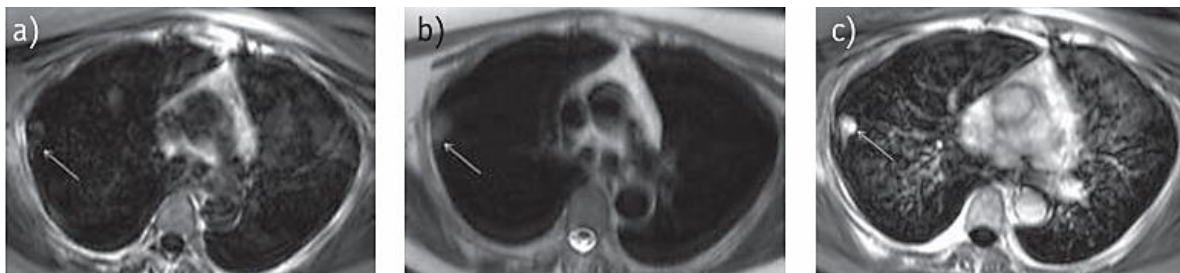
Axial magnetic resonance (MR) images of the right upper lobe. (a) T1-weighted and (b) T2-weighted images demonstrate a nodular lesion (arrow). (c) Post contrast T1-weighted image shows contrast enhancement of the lesion (arrow). Adapted from (de Wever et al., 2011)
